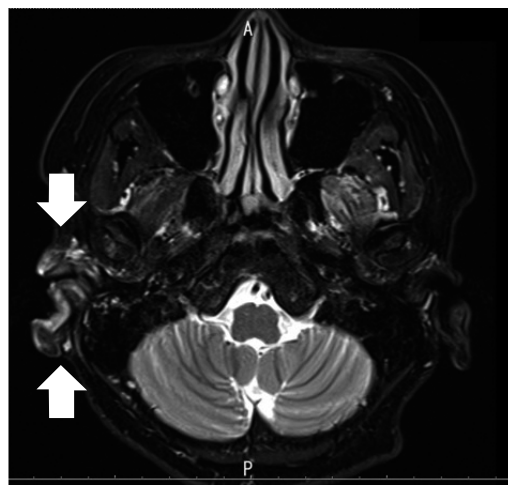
MRI of the patient's head. High signal intensity at the right inner auditory canal and the basal neural canal on T2-weighted imaging.
